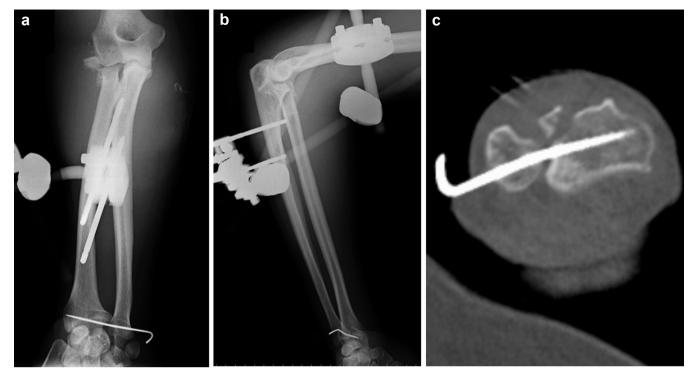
Radiographs immediately after the initial surgery: (a) Anterior-posterior view and (b) lateral view. Reduction and temporary stabilization of the elbow and pinning for the unstable DRUJ were performed. (c) Computed tomography axial view of the wrist after pinning. DRUJ, distal radioulnar joint.
